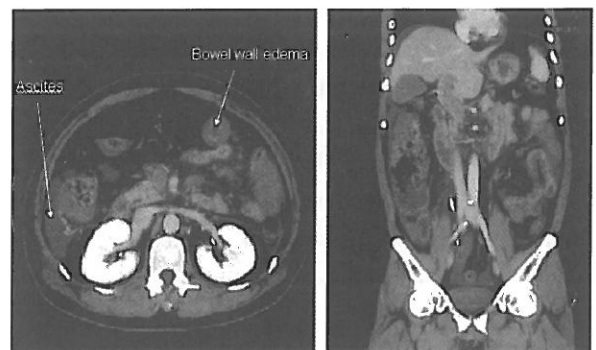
Day5 Computed tomography (CT) of the abdomen, with administration of contrast materials, showed extensive thrombosis with small intestinal wall edema and new onset ascites.
